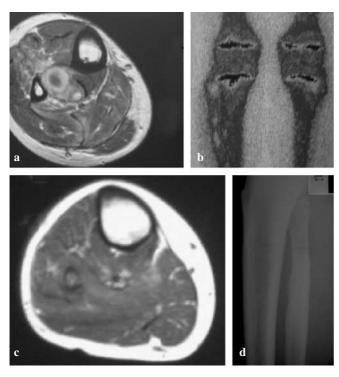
A 13-year-old boy with a limp (case 1). a MR image of the left leg at the onset. b TC-99m-MDP scan of the right and left legs. c MR image of the left leg 2 weeks after drainage. d Radiograph of the left leg 9 months after drainage
